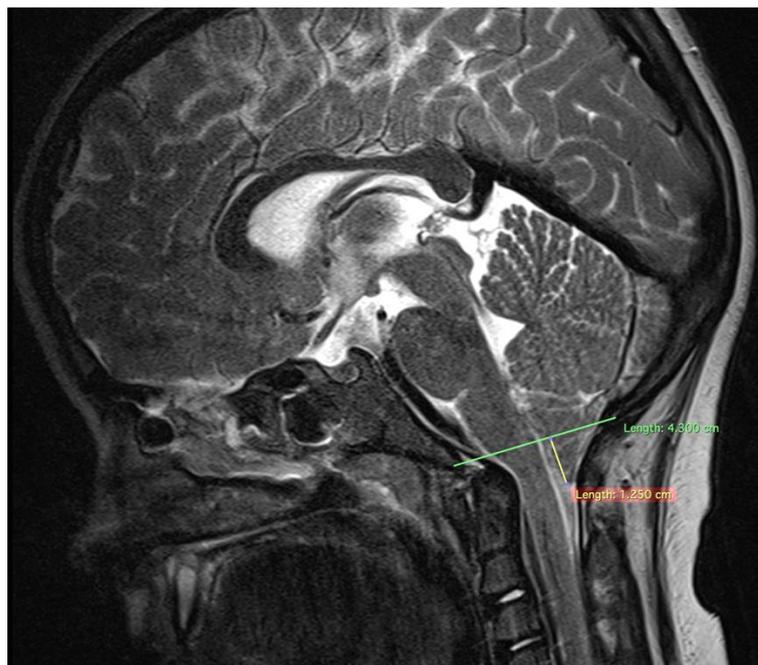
a) Sagittal T2-weighted MRI.
